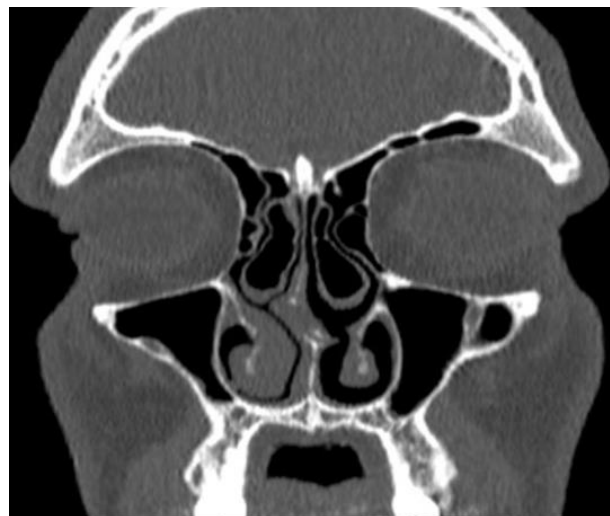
Coronal paranasal CT image of 20-year-old man with mladina type 4 nasal septal deviation and bilateral middle concha bullosa (arrows).
